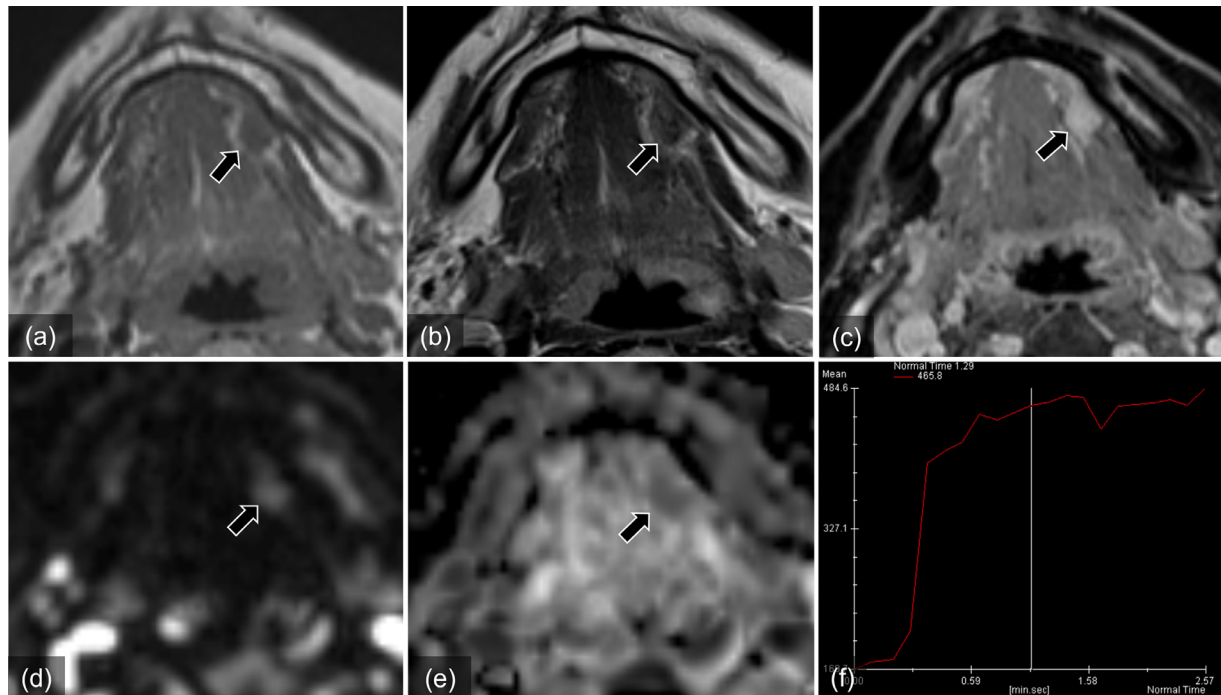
Magnetic resonance images of the mass on the left side of the floor of the mouth. (a) axial T1-weighted image (T1WI), (b) axial T2-weighted image (T2WI), (c) axial contrast-enhanced fat-suppressed T1WI, (d) axial diffusion-weighted image (DWI) ($b = 1000 \text{ s/mm}^2$), (e) apparent diffusion coefficient (ADC) map, (f) time-intensity curve of dynamic contrast-enhanced MRI. The mass shows isointensity relative to the surrounding muscle on T1WI (a, arrow), a heterogeneous low signal on T2WI (b, arrow), high signal intensity on DWI (d, arrow), and low signal intensity on the ADC map (e, arrow). The time-intensity curve shows a rapid initial enhancement, followed by a period of continuous enhancement at a slower rate (f). The mass shows uniform enhancement (c, arrow).
